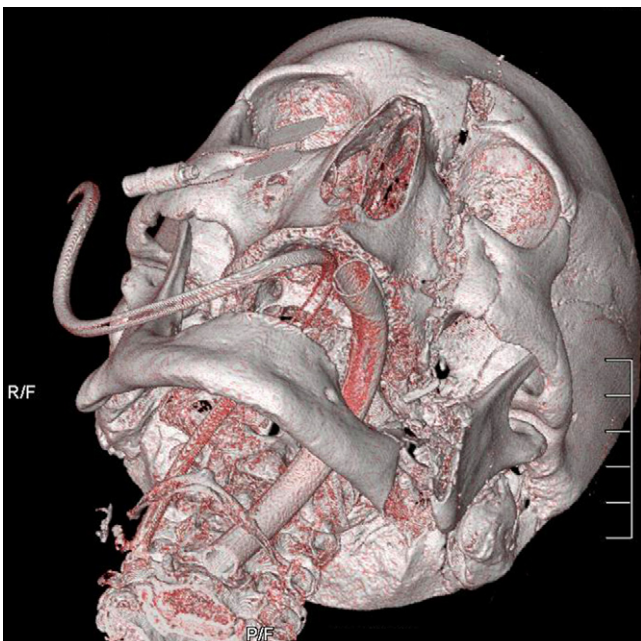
3D volumetric CT scan showing the extent of the bony injuries.
